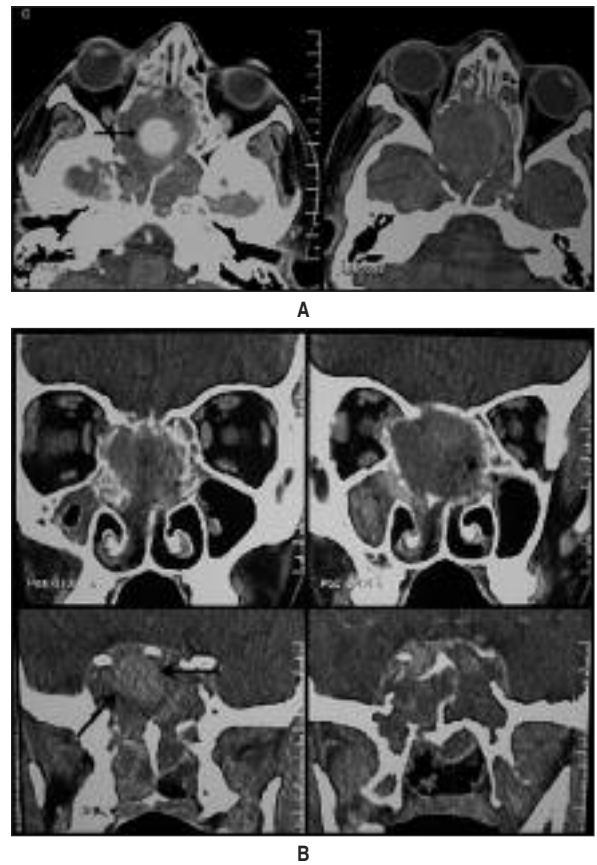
Precontrast and postcontrast axial (A) and postcontrast coronal (B) CT scans of the paranasal sinuses show a soft tissue mass with bony erosion and lateral expansion of the sphenoid and ethmoid sinuses. The mass shows central enhancement (arrow).
